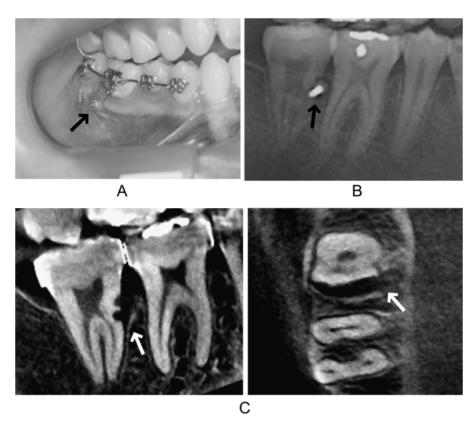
(A) Initial intraoral photograph of a 21-year-old male patient. A sectional multibracket appliance and miniscrew implant were placed between the first and second molar in the gingival region. There was no spontaneous pain, but slight miniscrew implant mobility was found. (B) Radiographic observation of the miniscrew implant and adjacent roots. (C) Computed tomographic images after removal of the miniscrew implant. Trauma was observed at the mesial root of the second molar. Furthermore, serious vertical resorption of adjacent dentoalveolar bone was found.
